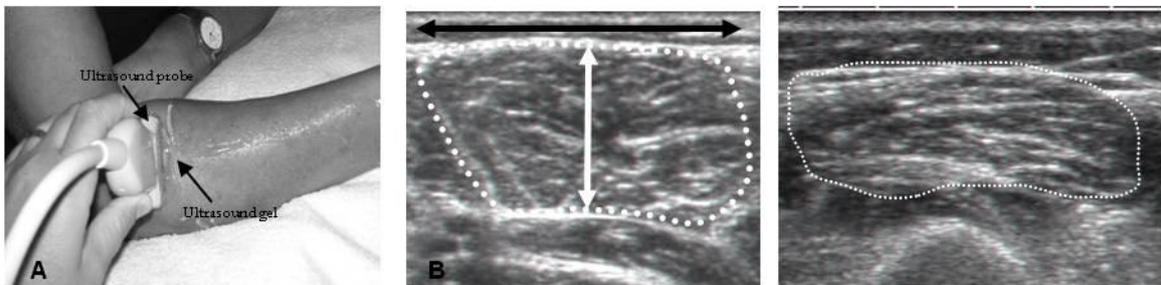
(A) The ultrasonic transducer was placed on the skin over the muscle EDC at a distance 15% distally from the muscle origin. (B) Transverse US image of EDC. The CSA is the area within the dotted line; the muscle thickness is indicated by the double headed white arrow and the muscle length indicated by the black double-headed arrow. (C) Transverse US image from one RA patient, taken when the fingers are fully extended.
